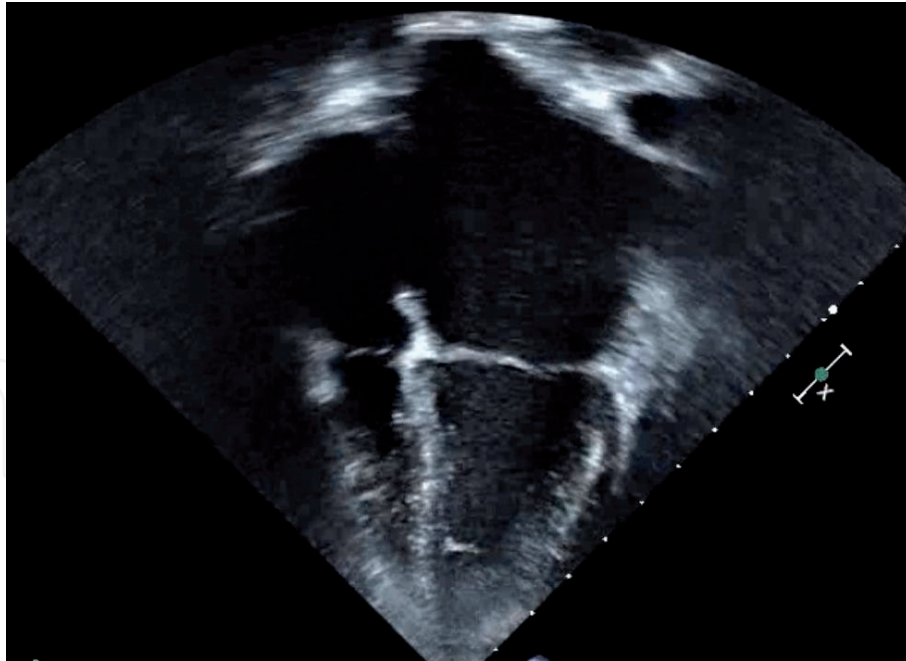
Two-dimensional, apical 4-chamber echocardiographic image depicting small, restrictive ventricles and significant biatrial enlargement in a patient with restrictive cardiomyopathy.
